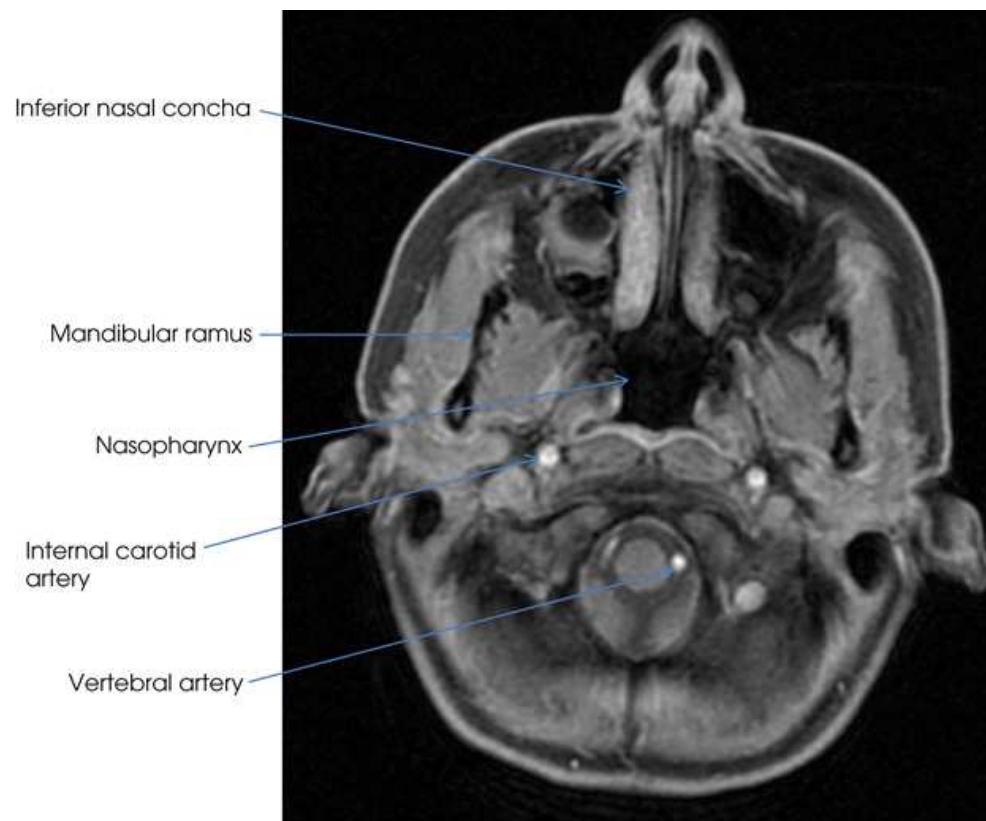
MRI corresponding to level G in Fig. 24.5B.
